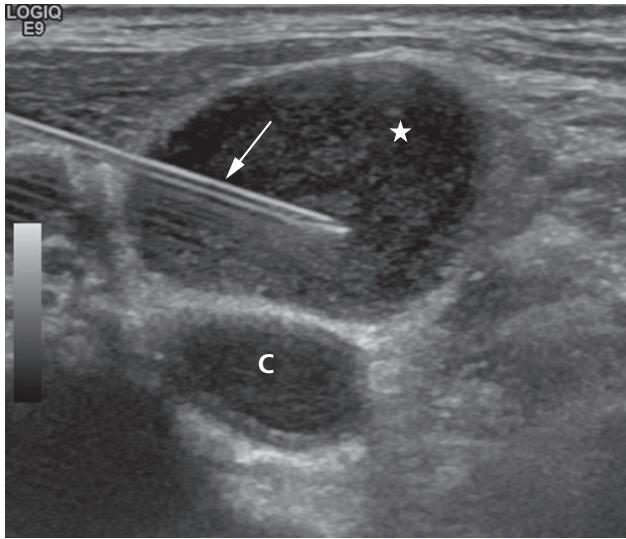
Ultrasound-guided FNA of a cervical lymph node showing the aspiration needle (arrow) within a necrotic lymph node (*). The carotid artery (C) is also visualized.
